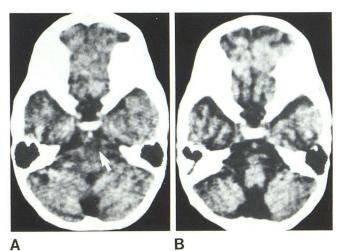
Case 11. Brainstem infarction. Plain CT scans. A, On admission. Attenuation value of basilar artery, 58 H (occlusion). Infarct at *arrow*. B, 16 days after onset. Attenuation value of basilar artery, 33 H.
